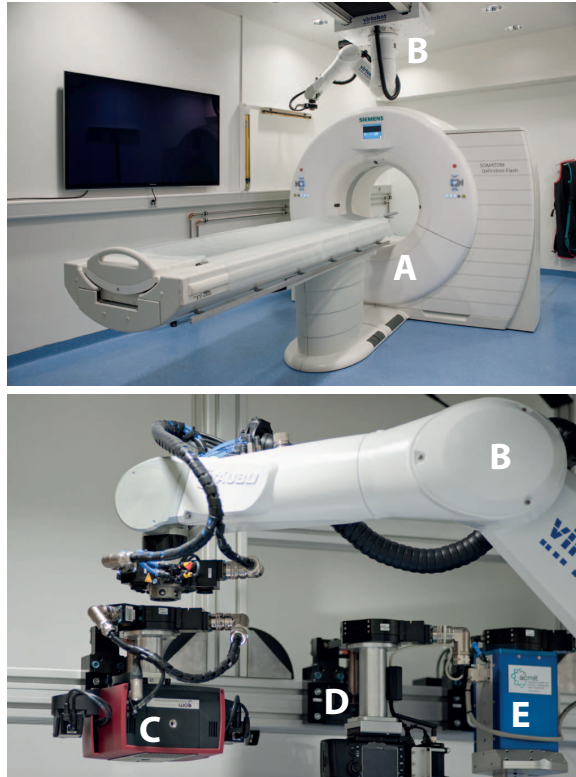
Virtopsy®system. The CT scanner (A) and its table are located within the reach of a ceiling mounted robot arm (B). The arm carries various tools which are picked up automatically, such as a 3D surface scanner (C), a photographic mirror reflex camera (D) and a system to target and place biopsy needles (E).
